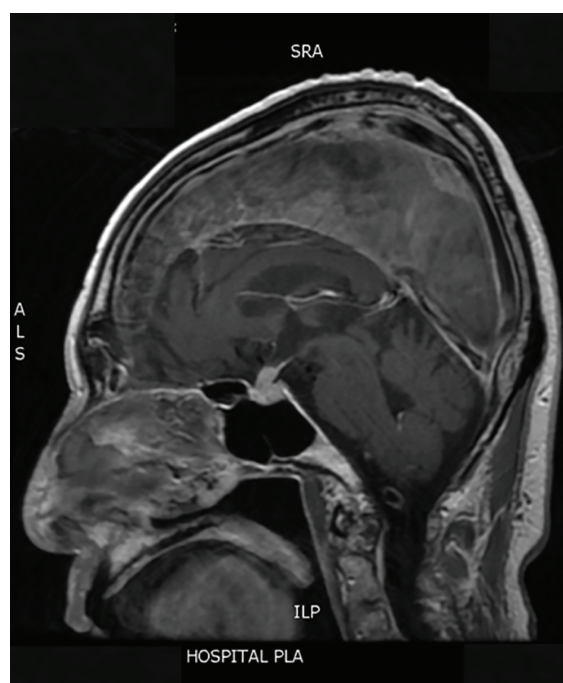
MRI indicated pituitary hypertrophy and thickening of pituitary stalk.
